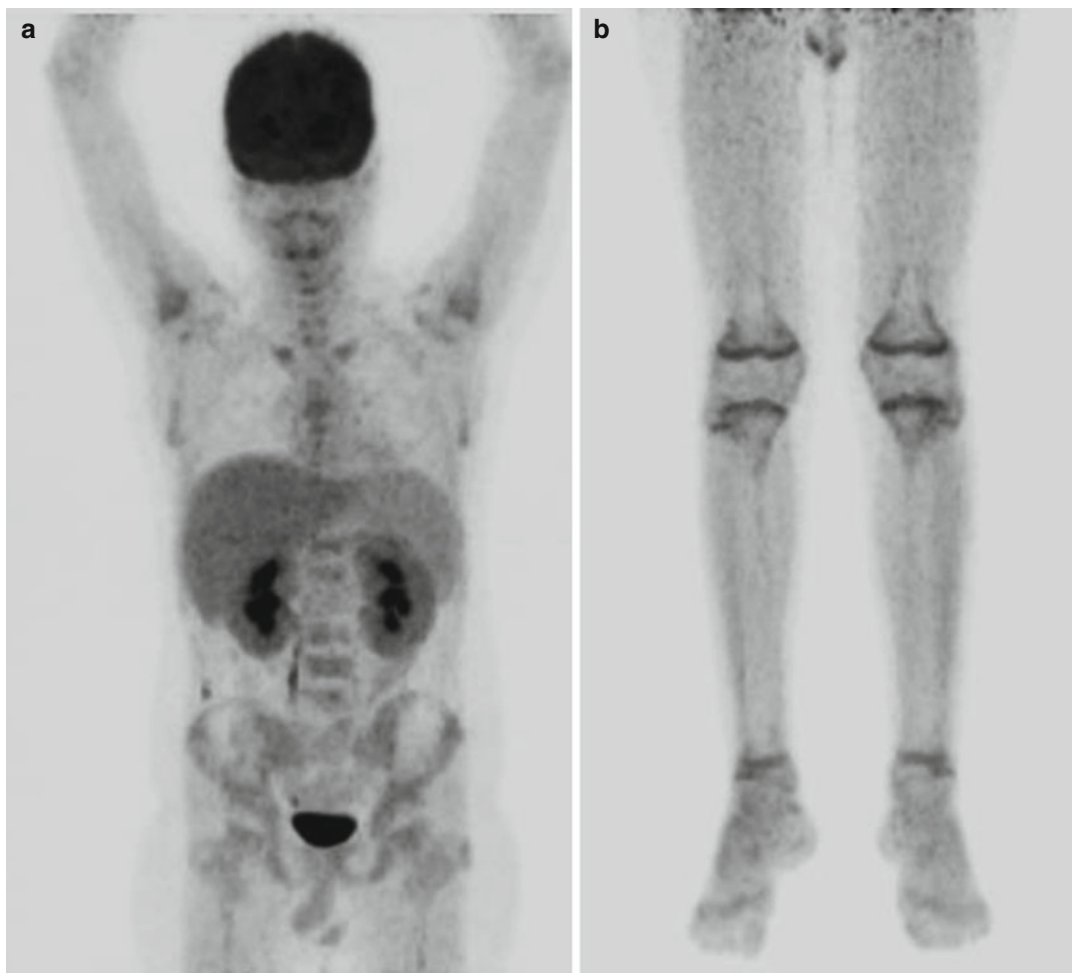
Four months after ASCT PET/CT study shows complete remission. In whole-body MIP images (a, b), no foci of increased metabolic activity are seen
